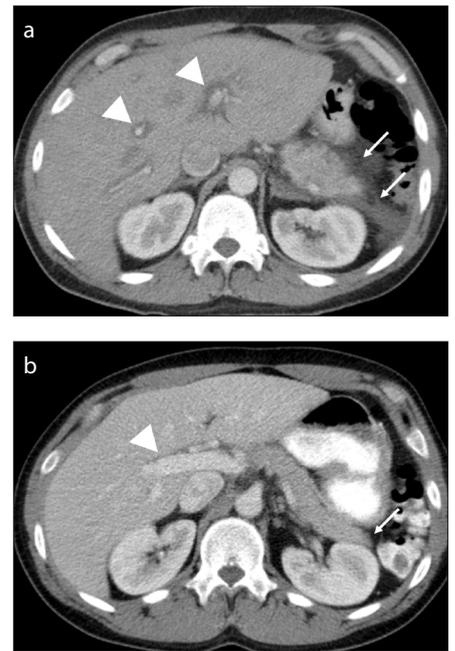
a, b. A 34-year-old man with a history of melanoma undergoing HDIL-2 treatment presented with abdominal pain. Axial contrast-enhanced CT image (a) shows edema and swelling of the pancreatic tail with peripancreatic fluid and fat stranding (*arrow*). The findings were consistent with HDIL-2 related pancreatitis. Additionally, prominent periportal edema is noted (*arrowhead*). HDIL-2 therapy was discontinued. Axial CT image obtained 1 month later (b) demonstrates resolution of the findings of pancreatitis (*arrow*) as well as periportal edema (*arrowhead*).
